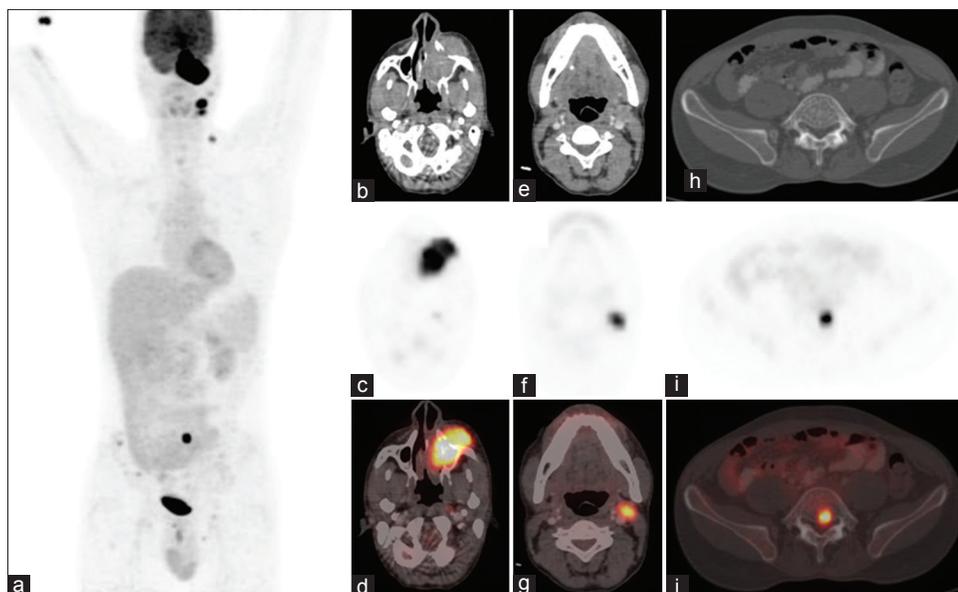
(a) Maximum intensity projection images showed fluorodeoxyglucose avid lesion in the left maxillary region with focal uptake in the left neck and lumbar region. (b-d) Positron emission tomography/computed tomography images revealed soft tissue density mass lesion involving the left maxillary sinus with erosion of medial, lateral and anterior walls of maxillary sinus extending into left orbit. (e-g) Positron emission tomography/computed tomography images showing multiple left cervical lymph nodes. (h-j) Positron emission tomography/computed tomography images showing marrow metastasis to body of L5 vertebra
